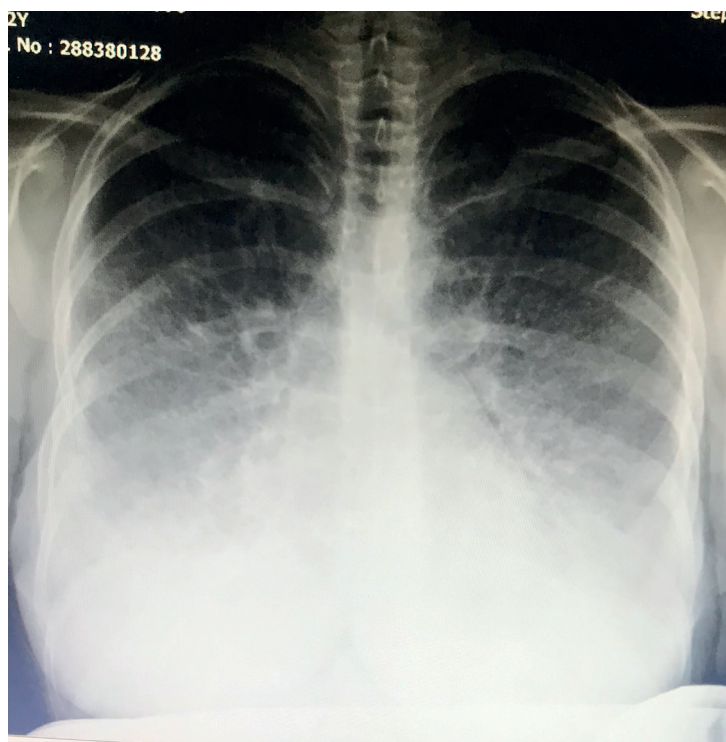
Posterior anterior chest radiography: bilateral diffuse calcified micronodular views at 35 weeks of the patient's gestation.
